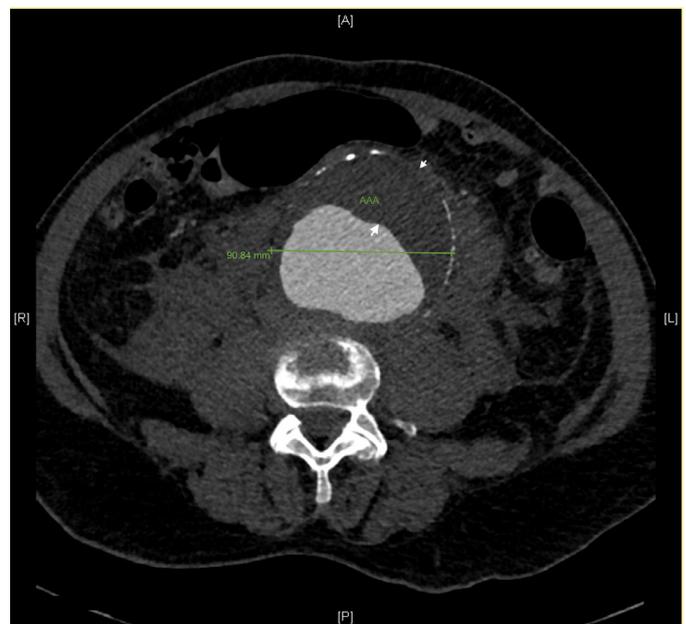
Computed tomographic scan of the abdominal aorta showing an aneurysm with eccentric thrombus in the anterior aspect (arrows). AAA:abdominal aortic aneurysm.
